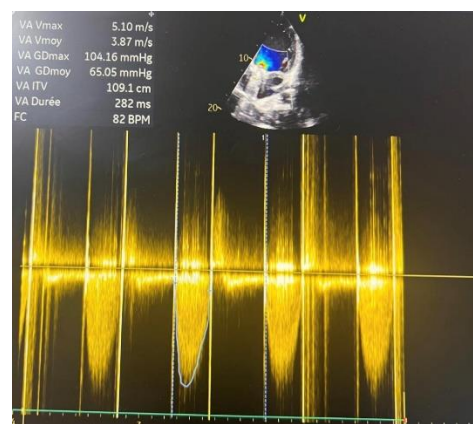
Continuous doppler on the aortic prosthesis showing a high mean transprosthetic gradient of 65 mmHg
